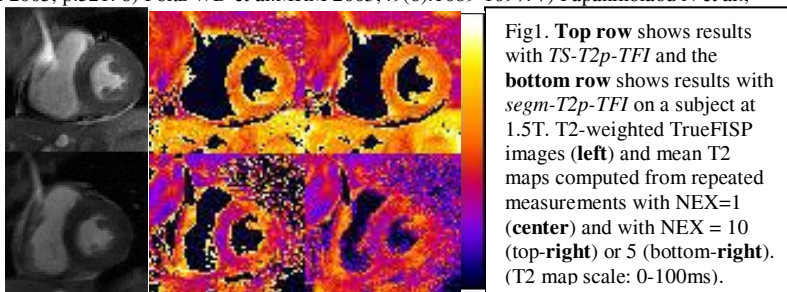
Top row shows results with *TS-T2p-TFI* and the bottom row shows results with *segm-T2p-TFI* on a subject at 1.5T. T2-weighted TrueFISP images (left) and mean T2 maps computed from repeated measurements with NEX=1 (center) and with NEX = 10 (top-right) or 5 (bottom-right). (T2 map scale: 0-100ms).
